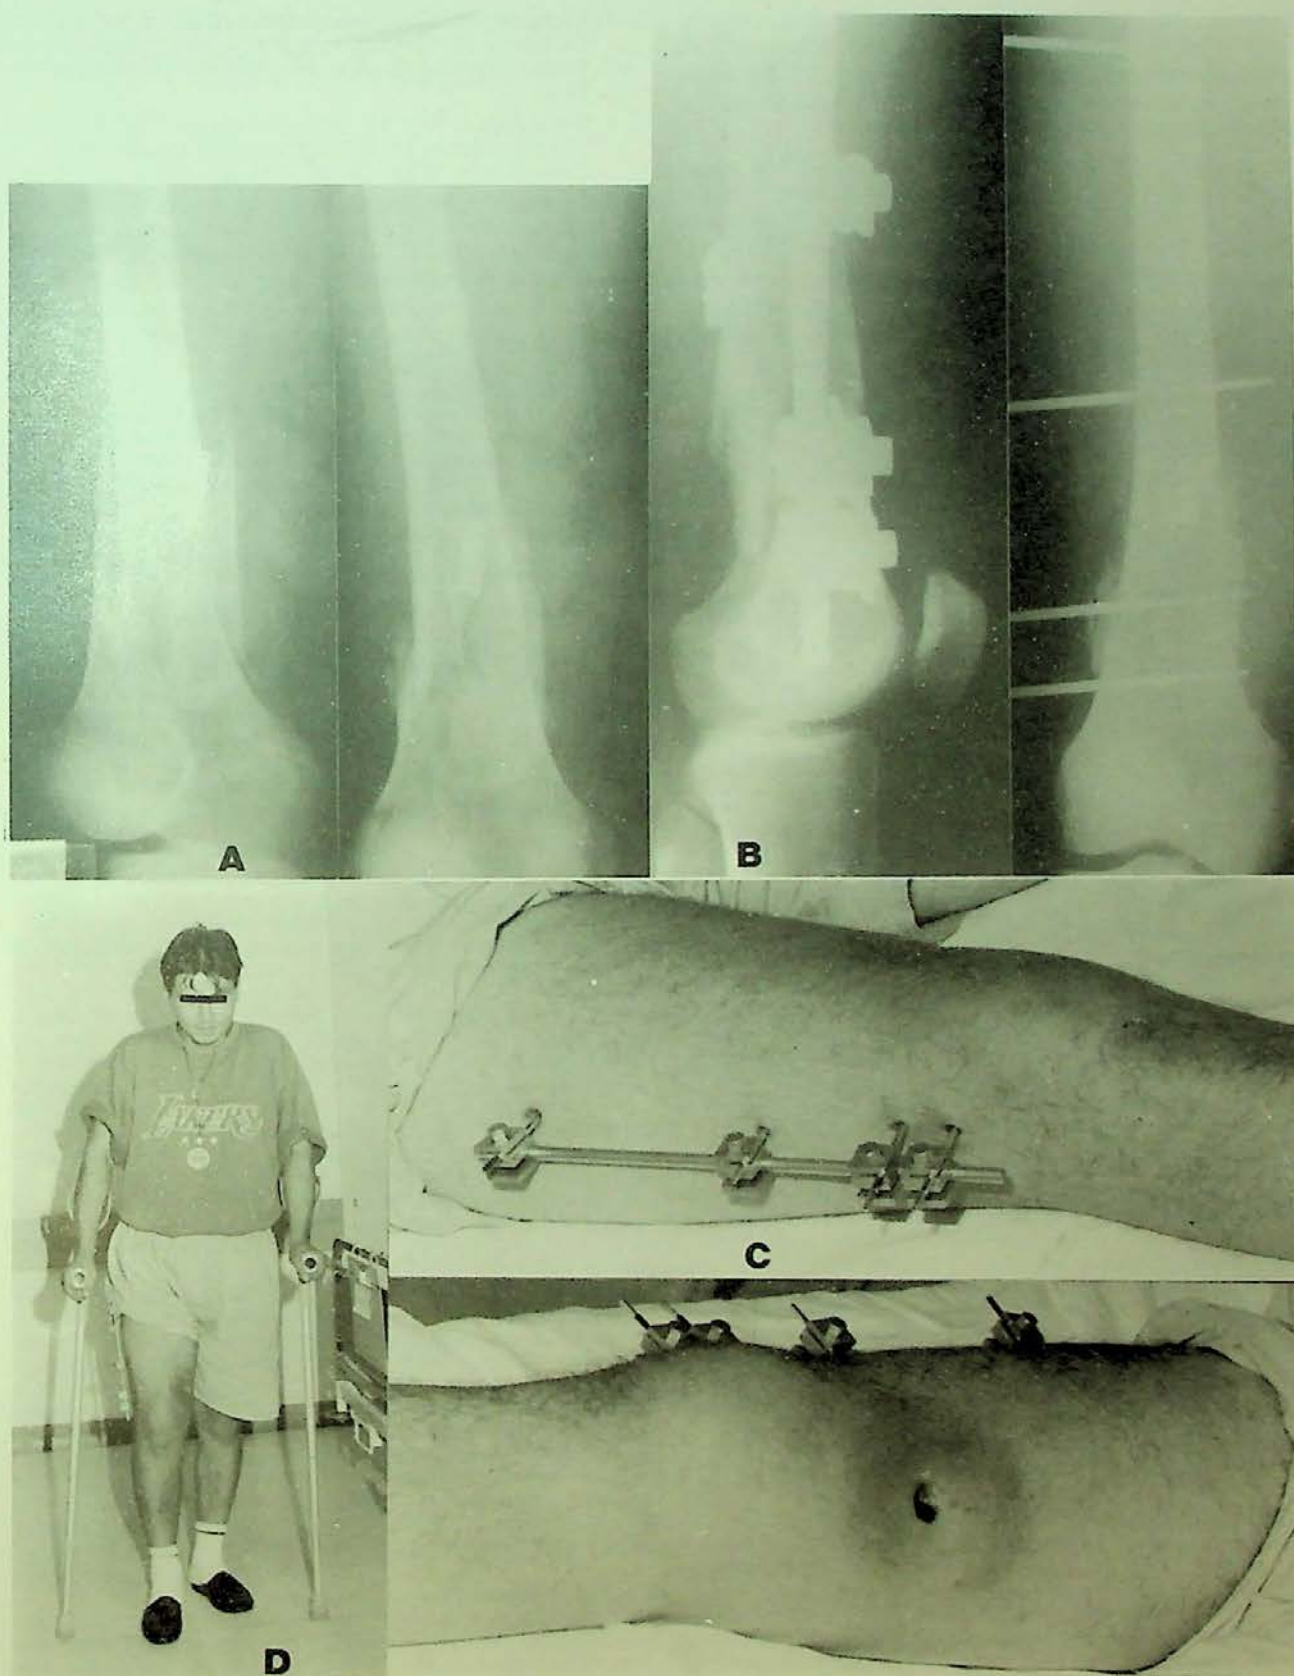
CMC fixator applied in a wounded subject: A, roentgenogram of the injury; B, postoperative roentgenogram; C, the fixator as applied in the patient; D, day 6 after the surgery.
